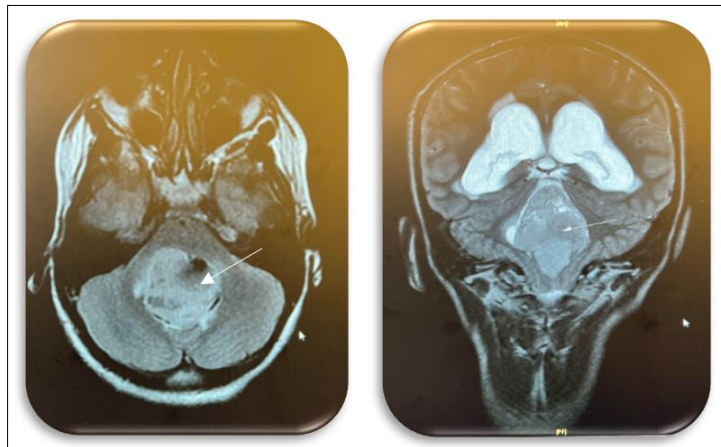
The axial Flair and coronal T2 phases of the magnetic resonance imaging revealing a tumor in the posterior fossa arising from the vermis (white arrow) causing extensive hydrocephalus
